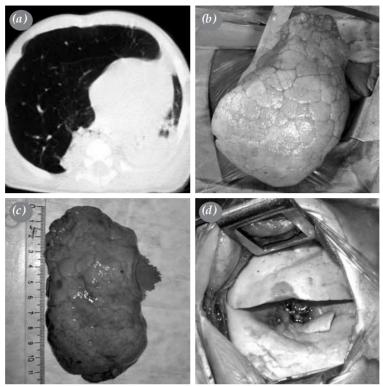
Thoracic computed tomography (a) image of 70-day-old female patient with congenital lobar emphysema and view of intraoperative appearance of middle lobe (b), resection material (c) and upper and lower lobes after middle lobectomy (d).
